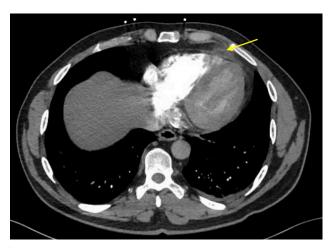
Computed tomography scan of the chest demonstrating epipericardial fat necrosis (yellow arrow) as an oval-shaped mass, with a central hypodense area, surrounded by a rim of hyperdense, inflammatory tissue.
